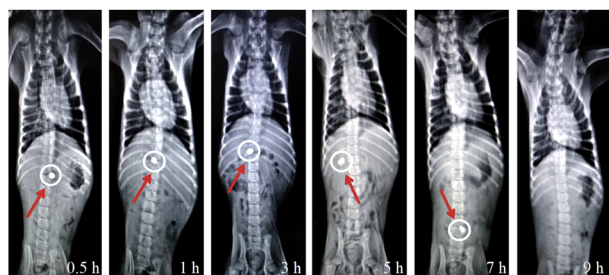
In vivo* X-ray photographic images of AVH tablet formulation (AVHF) showing its transit behavior in GIT.
